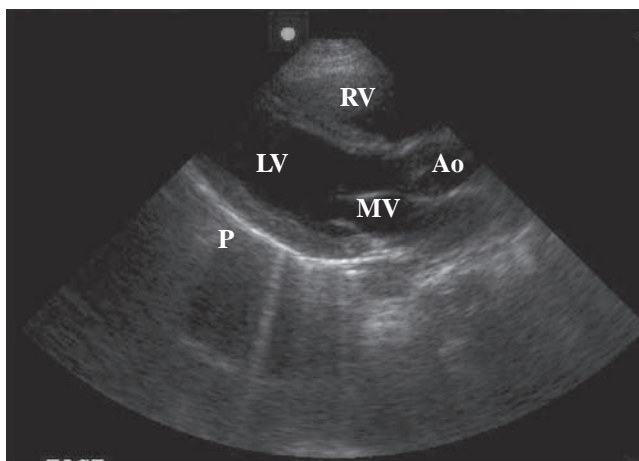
Normal parasternal long cardiac view. Note the right ventricle (RV), left ventricle (LV), mitral valve (MV), aortic root (Ao), and pericardium (P). Fluid will accumulate just above the pericardium in a pericardial effusion.
